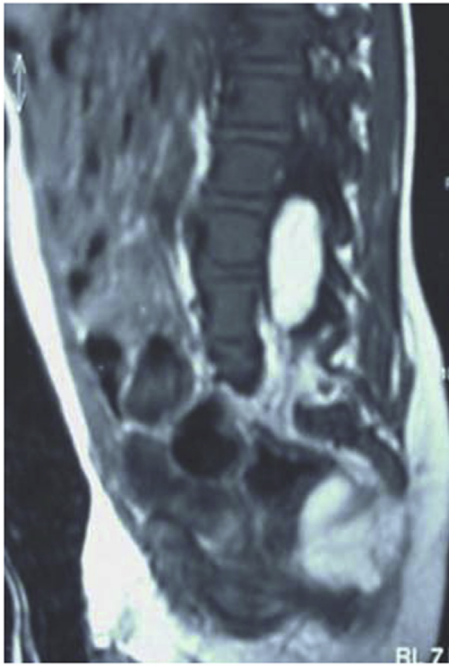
Mid-sagittal T1-weighted image of a intradural lipoma.
